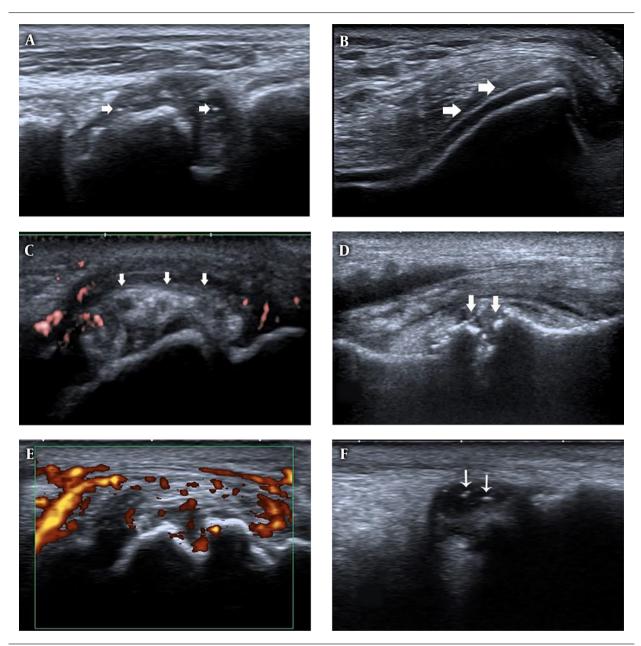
Ultrasound features of joints in first gout attack and asymptomatic hyperuricemia (AHU). A, First metatarso-phalangeal joints (1st MTP) longitudinal view, B-mode ultrasound shows synovial thickening and hyper echoic foci (white arrows) in patients with first gout attack. B, Knee transverse view, B-mode ultrasound shows double contour (DC) sign (white arrows) on the surface of the cartilage in patients with first gout attack. C, 1st MTP longitudinal view, tophi (white arrows) with surrounding power Doppler signal in patients with first gout attack. C, 1st MTP longitudinal view, tophi (white arrows) with surrounding power Doppler signal in patients with first gout attack. F, Ankle longitudinal view, hyperechoic foci (white arrows) inside the synovial fluid.
